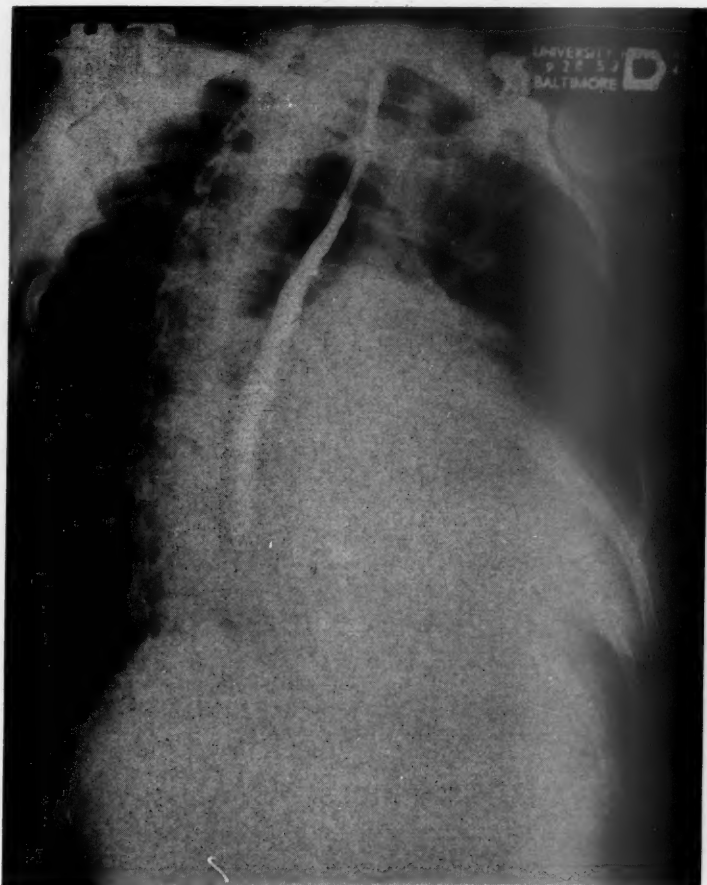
Roentgenogram (right anterior oblique). The heart is enlarged anteriorly and posteriorly, with deviation of the barium filled esophagus posteriorly. The pulmonary artery segment is prominent.
